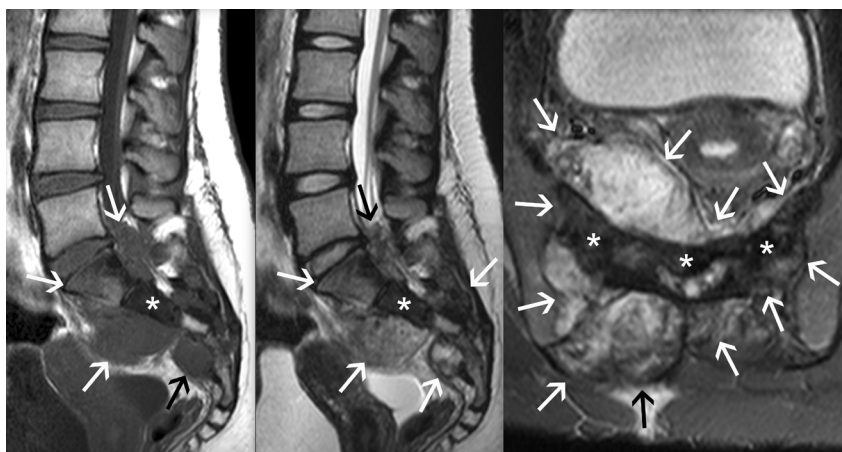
MRI of a 15-year-old girl with sacral osteosarcoma. Sagittal T1WI (left), sagittal T2WI (center), and axial contrast-enhanced fat-suppressed T1WI (right), showing a large expansile mass centered at S2 (straight arrows) with diffuse osseous infiltration, destruction of the posterior portion of the right ilium, and an extensive soft-tissue component extending into the presacral space and spinal canal. Contrast enhancement is more conspicuous in the soft-tissue component. Areas of low signal intensity across all sequences (asterisks) represent mineralized osteoid matrix.
